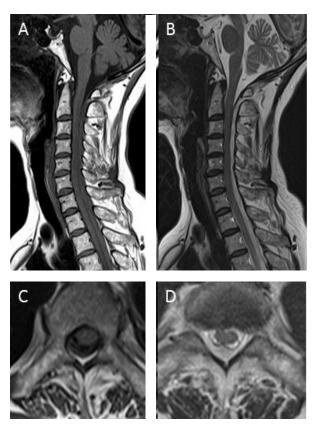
The T1- (A, C) and T2- (B, D) weighted images of the initial spinal MRI show a thick homogenous epidural hematoma compressing the spinal cord dorsally. C and D are axial images of the T1 level.
